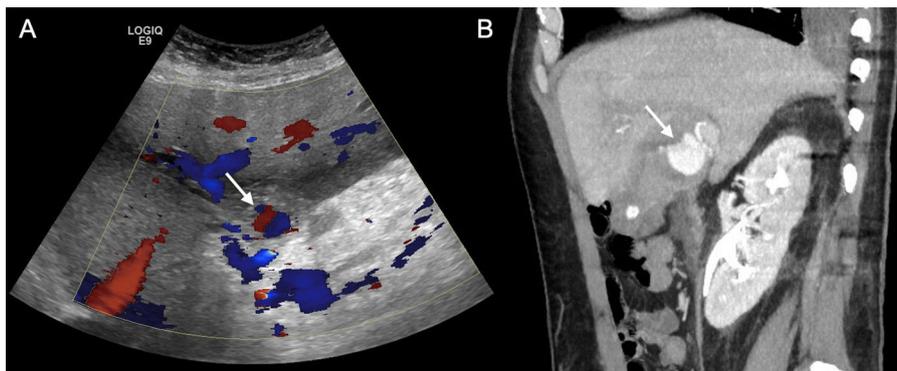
50-year-old man who came in with arterial hypotension, fever and pain in the right hypochondriac region. Blood tests showed increased acute phase reactants. With clinical suspicion of complicated biliary colic, ultrasound of the abdomen and pelvis (A) showed signs of acute calculous cholecystitis and, when colour Doppler was applied, a structure with the "yin-yang" sign was detected in the hepatic hilum (arrow). Sagittal maximum intensity projection reconstruction of the arterial phase CT angiography (B) confirms a pseudoaneurysm of the right hepatic artery (arrow). It progressed to haemorrhagic cholecystitis and urgent embolization of the pseudoaneurysm was performed.
